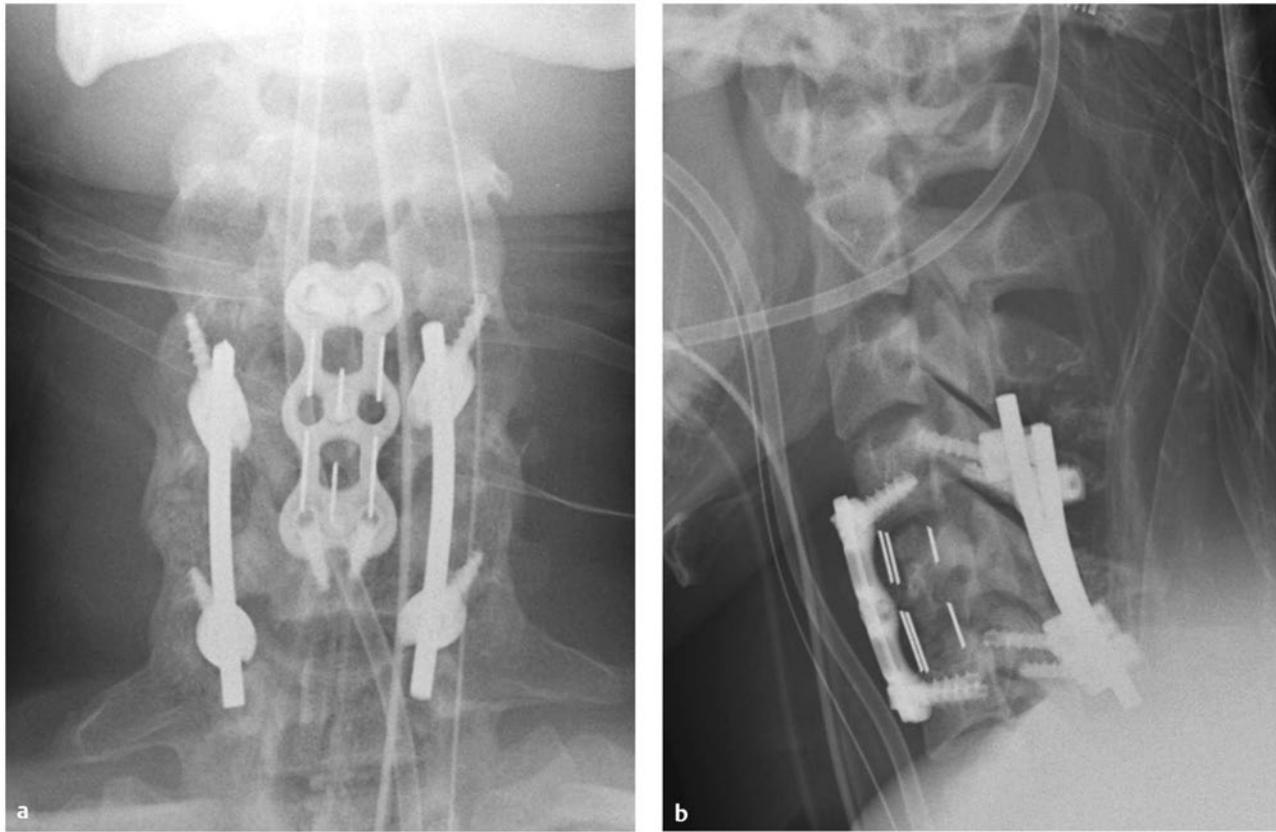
Cervical fracture–dislocation. Postoperative (a) anteroposterior and (b) lateral radiographs of the patient in ▶ Fig. 61.14 demonstrating a combined anterior and posterior approach for decompression, reduction, and stabilization of his cervical fracture–dislocation. The initial stage consisted of a C5 corpectomy, reduction, placement of a synthetic interbody graft, and anterior plating from C4 to C6. This was followed by posterior segmental instrumentation and fusion from C4 to C6.
